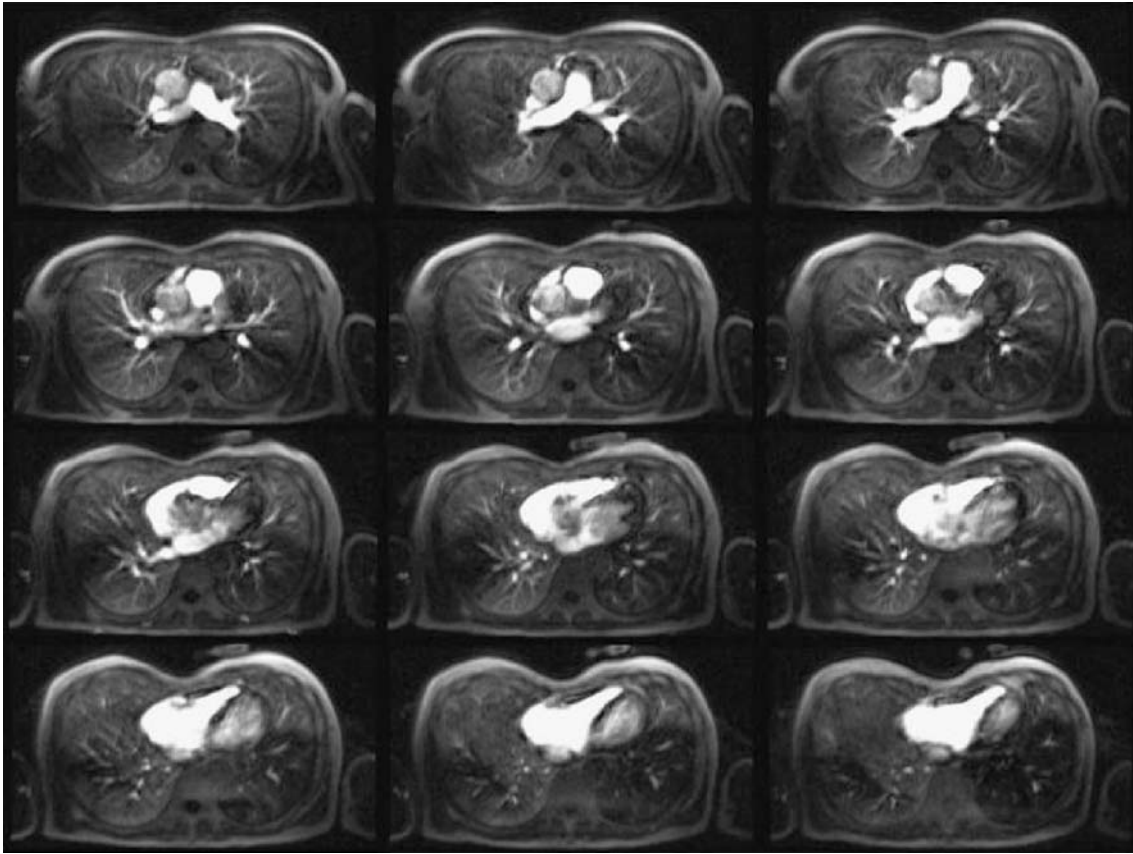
Magnetic resonance imaging (MRI) perfusion study. MR perfusion images of patients with occlusion of the left superior pulmonary vein from Fig. 8. Axial plane MRI images from the pulmonary apex to the base show corresponding perfusion defects through the left lung
